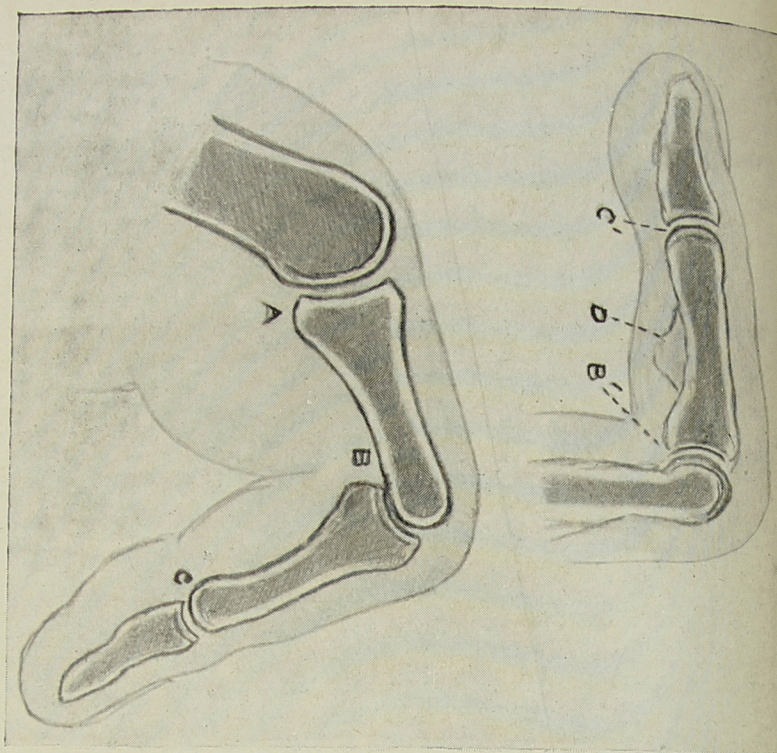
Radiographs from typical case of Dupuytren's contraction (little finger of each hand). For explanation see text.
